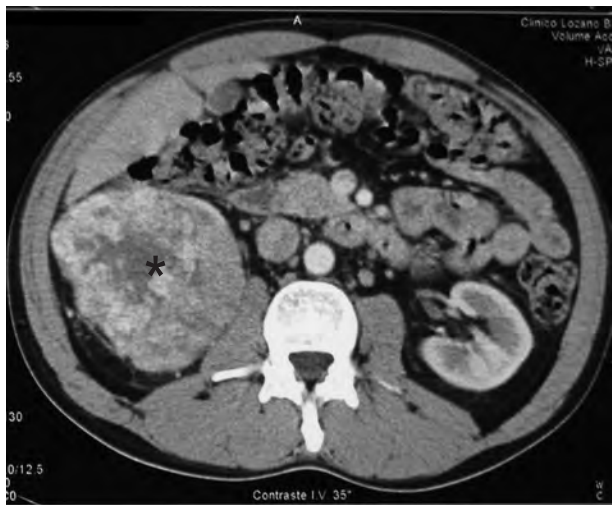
Abdominal CT scan: right kidney image compatible with hypernephroma (asterisk).
